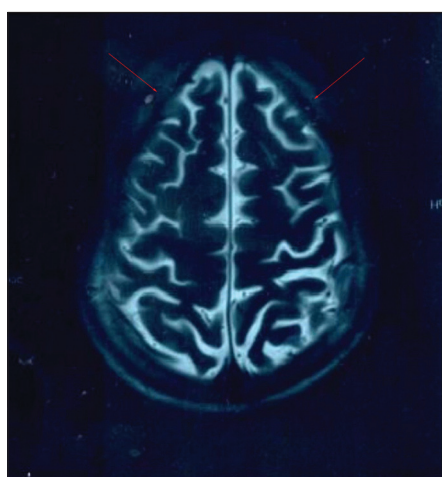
T2 weighted MRI images of the brain showing cortical atrophy
